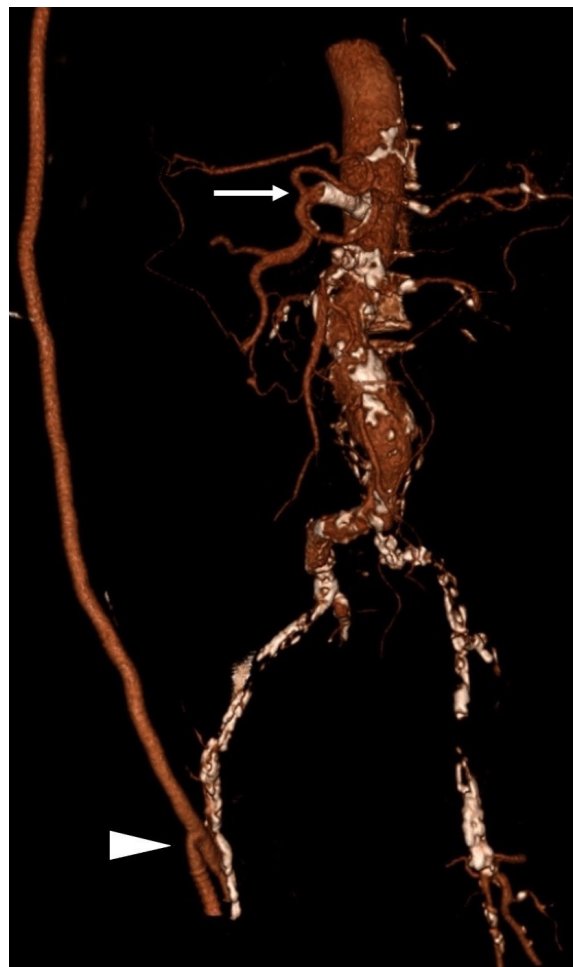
CT angiography 3D reconstruction showing a patent celiac artery stent and perfusion of the arterial branches (arrow) as well as the patency of revascularization of the right lower limb with an axillofemoral and femoropopliteal sequential bypass (arrowhead)
